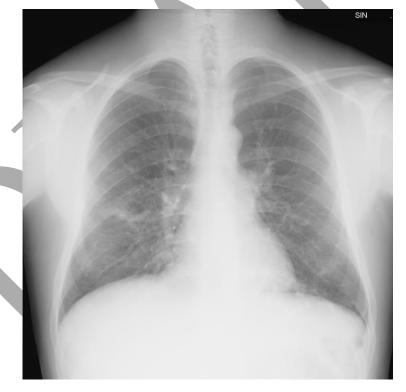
X-ray Medical Image
